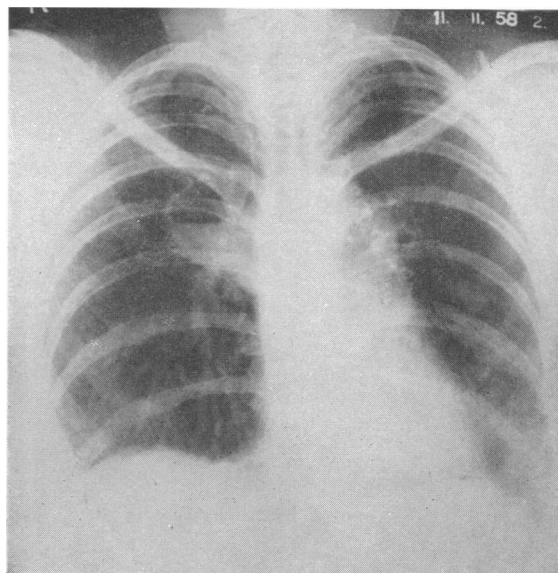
Case 4. Radiograph of chest, November, 1958.
